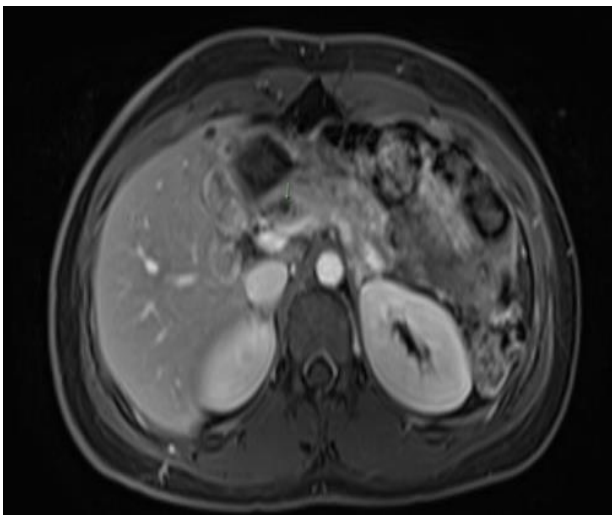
MRI abdomen axial plane demonstrating head of pancreas lesion.
